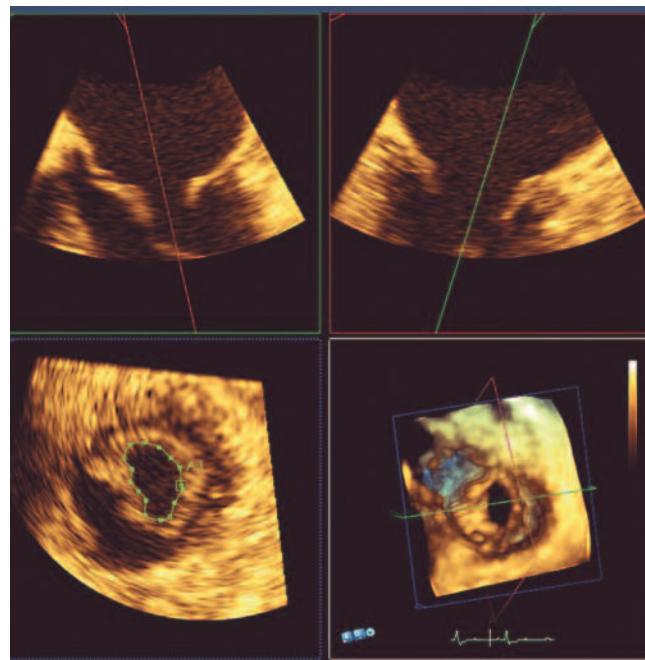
3D echocardiographic view of valvular mitral stenosis. Views of the mitral valve leaflets are acquired at 90° perpendicular views from the same cardiac cycle, using a 3D echocardiography probe at mid-diastole when the mitral valve tips show maximal excursion (red and green lines). This is used to give a volume-rendered en-face view of the mitral valve, used to calculate mitral valve area by planimetry (tracing the orifice). This patient has moderate mitral stenosis with a valve area of 1.3 cm².
